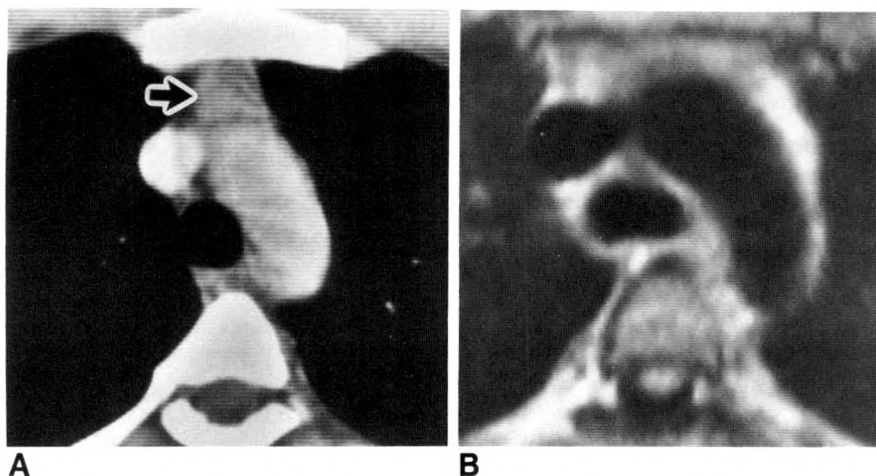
Case 9: Thymic hyperplasia in 24-year-old woman with myasthenia gravis in whom CT was considered better than MR for defining thymus.
